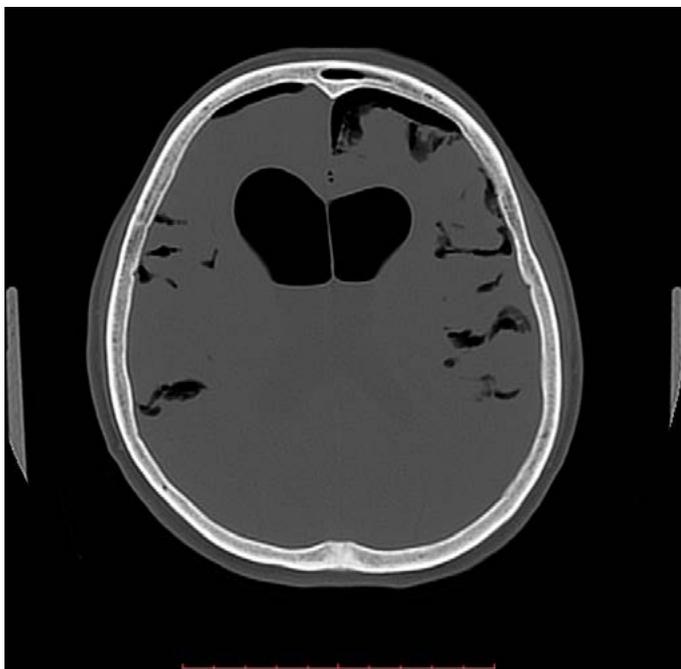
Computed tomography scan, axial view, performed 7 days after surgery. Pneumocephalus with compression of frontal lobes and presence of air in anterior horns of lateral ventricles are seen.
